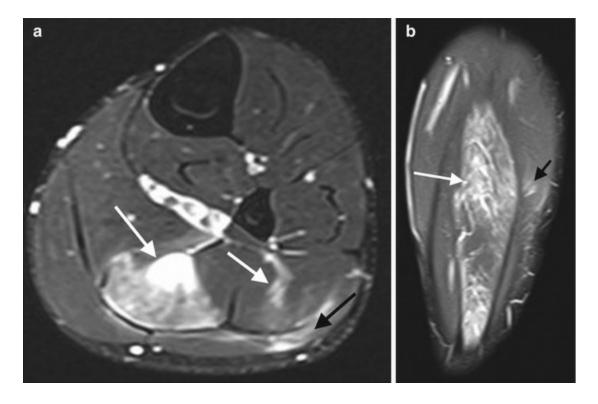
A 24-year-old athlete with acute calf pain. Axial (a) and coronal (b) fat-suppressed T2-weighted MRI show a bifocal musculo-aponeurotic strain of the soleus (grade 2, *white arrows*) and lateral gastrocnemius muscles (*black arrow*)
